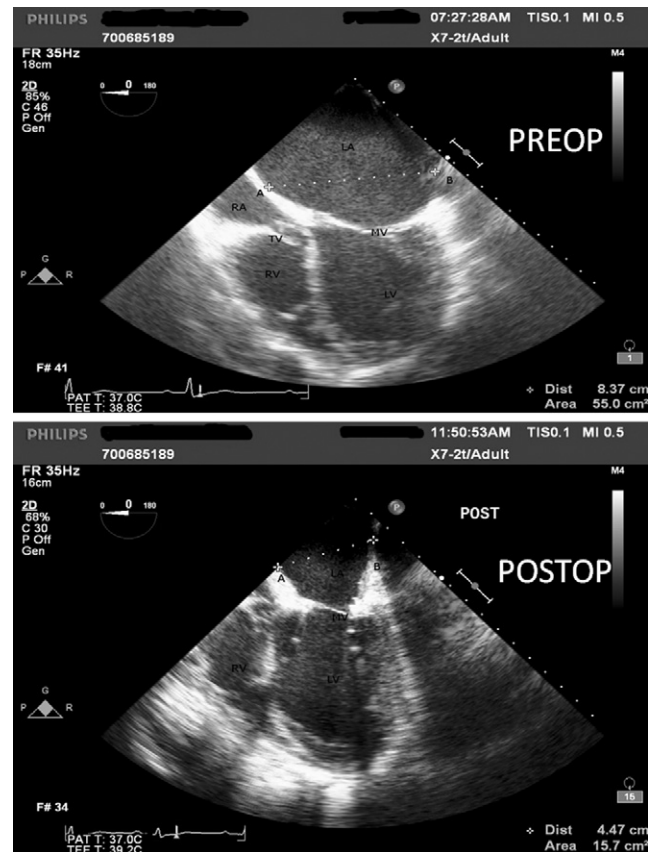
Representative preoperative and postoperative echocardiography findings. The diameter of giant left atrium was 83.7 mm preoperatively and it was considerably reduced to 44.7 mm by using the reef-imbriate suture technique. LA: left atrium; LV: left ventricle; AB: left atrium diameter; and MV: mitral valve.
